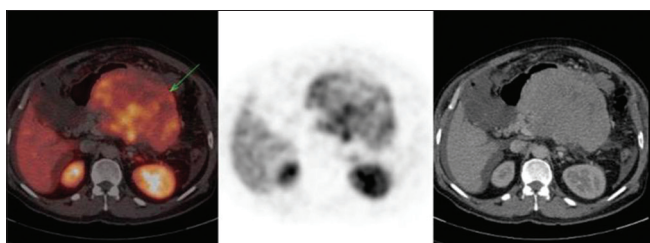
Axial positron emission tomography/computed tomography images of the abdomen showing large well-circumscribed poorly enhancing pancreatic mass arising from the body of the pancreas
